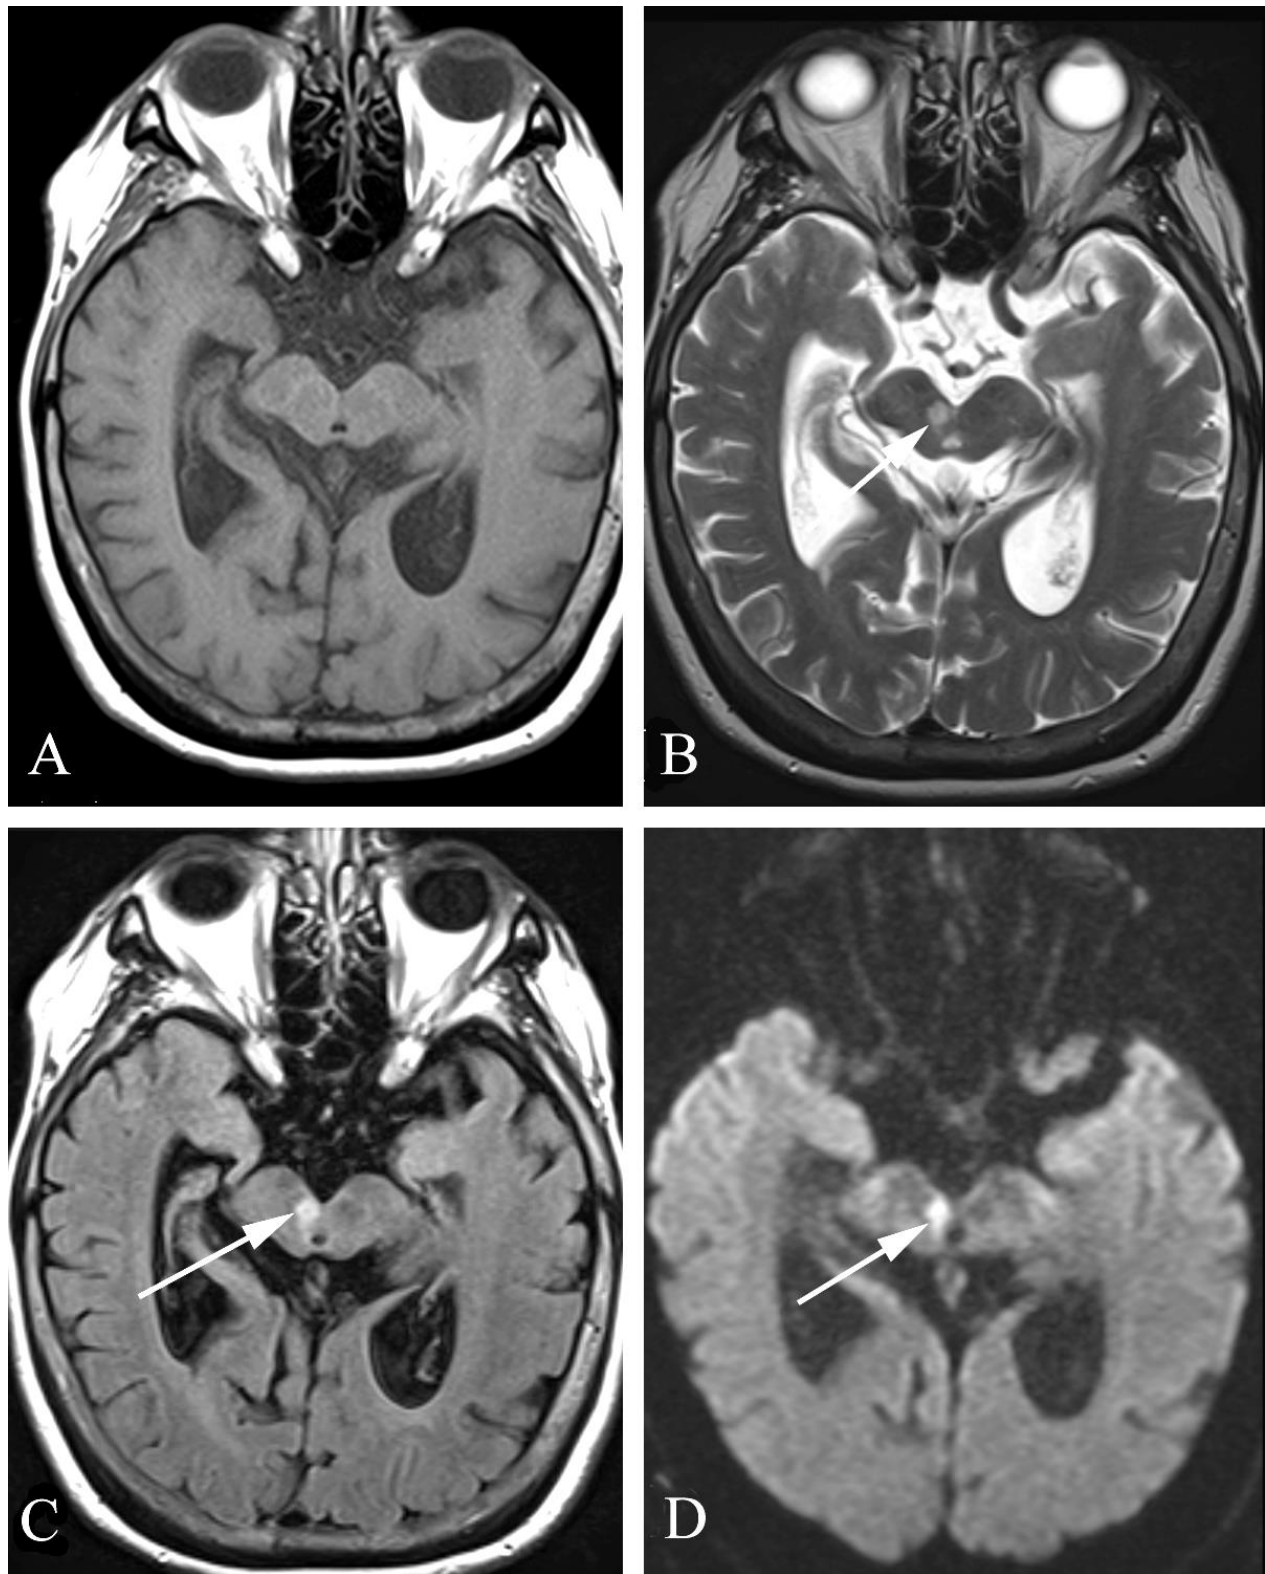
Stroke in a 70 year old woman with diplopia (and dizziness) beginning 4 days prior to the MR study. A. Axial T1 weighted MR is normal. B. Axial FLAIR MR shows a focus of increased signal intensity in the right brainstem (arrow). C. Axial FLAIR image also shows abnormal signal in the right brainstem (arrow). D. Axial diffusion weighted image demonstrates increased signal indicating restricted diffusion, characteristic of a stroke.
